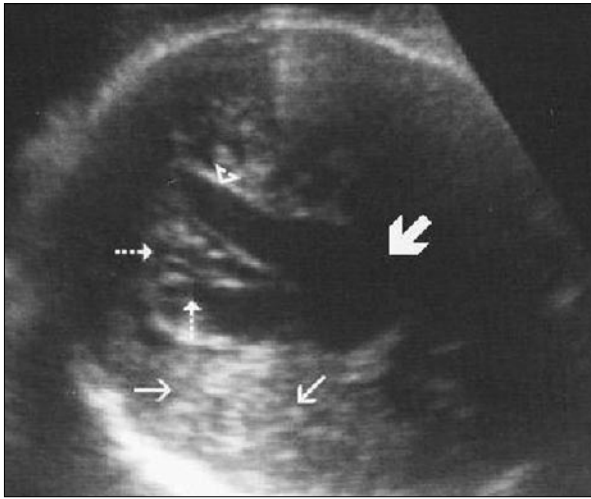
Obstetric sonographic examination demonstrates an intracranial high-flow pial arteriovenous fistula (*dashed arrows*), draining into the vein of Galen. Hyperechoic parenchyma of the right parietooccipital lobe (*thin arrows*), dilated vein of Galen (*thick arrow*), and straight sinus (*arrow head*) can also be seen.
